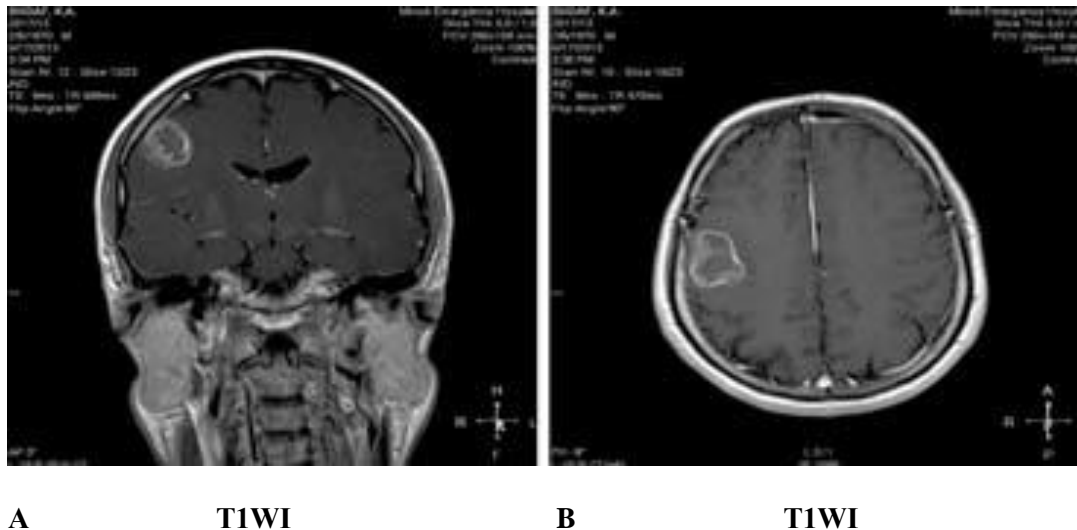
Pre-surgery MRI of patient B., 43 years old. Diagnosis: glioblastoma of the right parietal lobe. A – T1WI mode in frontal projection, B – T1WI-mode in axial projection
